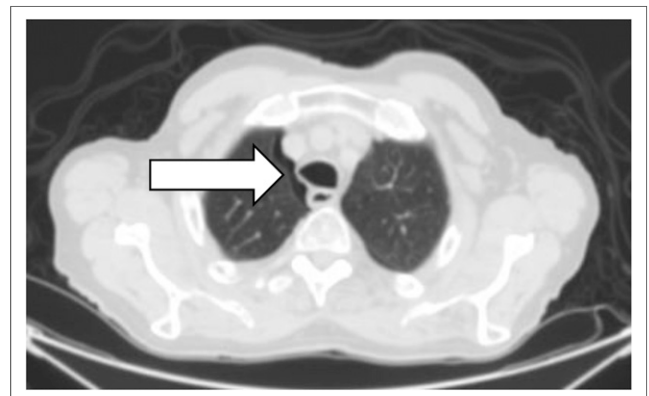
Pneumothorax on axial CT image displayed in lung window 1,500 and level -550.
